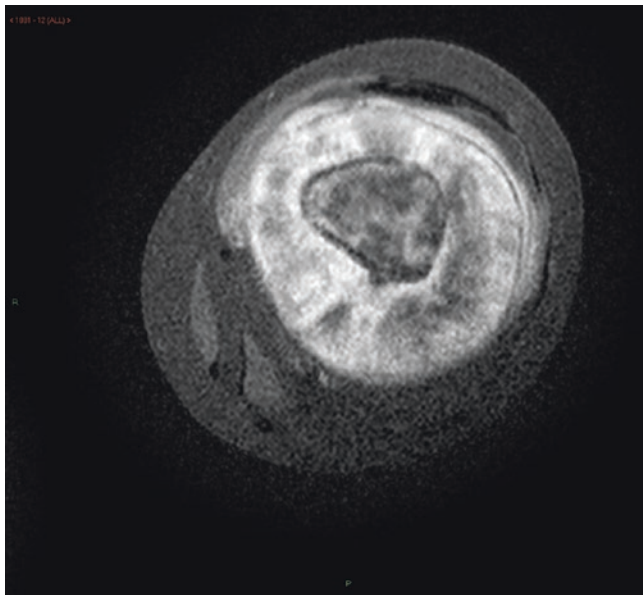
Florid enhancement of the lesion on contrast enhanced axial MRI of the distal femur
